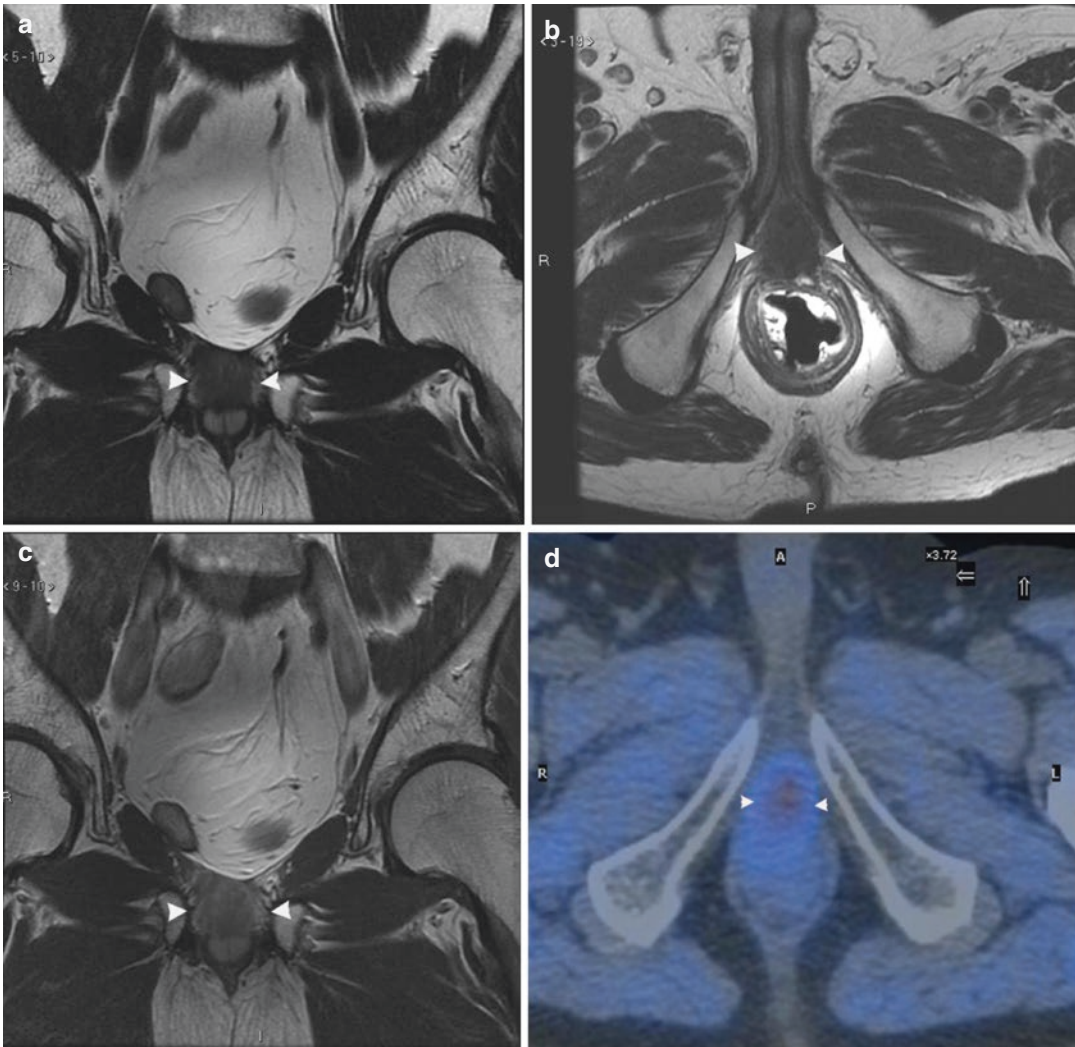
A 56-year-old man with rising PSA after radical prostatectomy. (a, b) MR T2-weighted coronal and axial images with endorectal coil show a soft-tissue mass (arrowheads) anterior to the rectum. (c) Post-contrast
